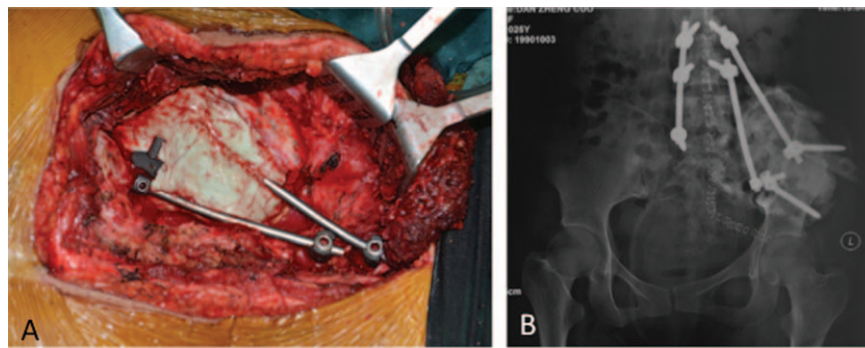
(A) Intraoperative photo shows the tumor was removed and the bony defect is filled with bone cement, and the lumbopelvic integrity is reconstructed with a spinal screw-rod system. (B) Postoperative plain radiography shows the reconstruction.
